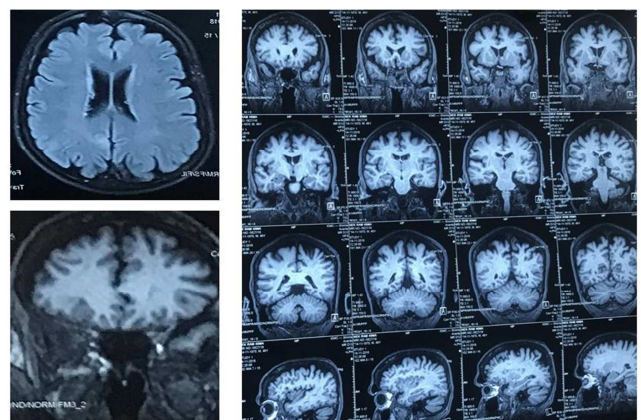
(a-c): MRI brain shows multiple sub-ependymal nodules of varying sizes along bilateral ventricles, hypo-intense on T1 and hyper-intense on T2. Also seen are nodules bilateral parietal, right frontal and left occipital lobe of cortex.
